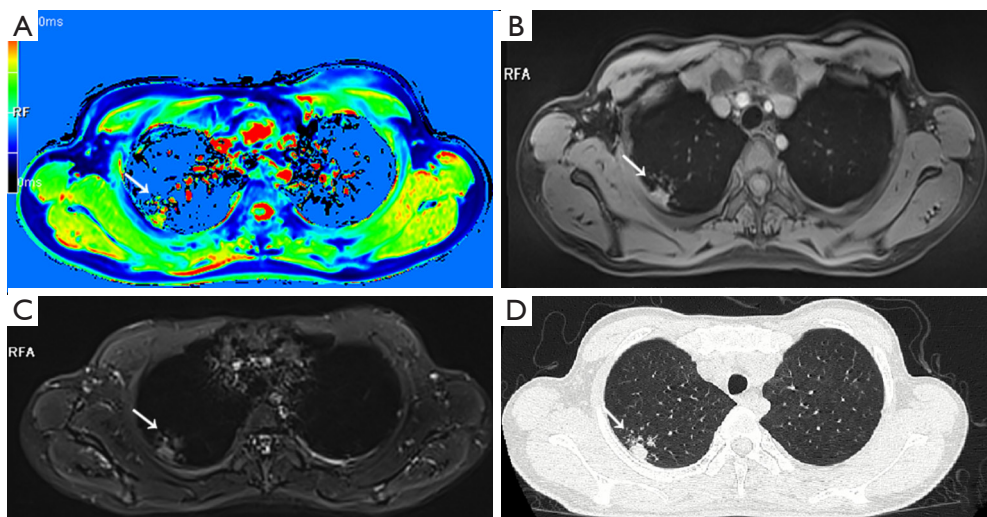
A pulmonary tuberculosis (TB) patient with lesions in the right superior lobe. (A) T1-mapping pseudocolor map; (B) T1-star VIBE; (C) T2-fBLADE; (D) computed tomography (CT; lung window). A TB lesion with the tree-in-bud sign (D, white '→'), located in the right superior lobe, can be clearly detected by T1-mapping (A, white '→'). The lesion was slightly more intense in T1-star VIBE (B, white '→'), and T2-fBLADE (C, white '→'). VIBE, volumetric interpolated breath-hold examination.
